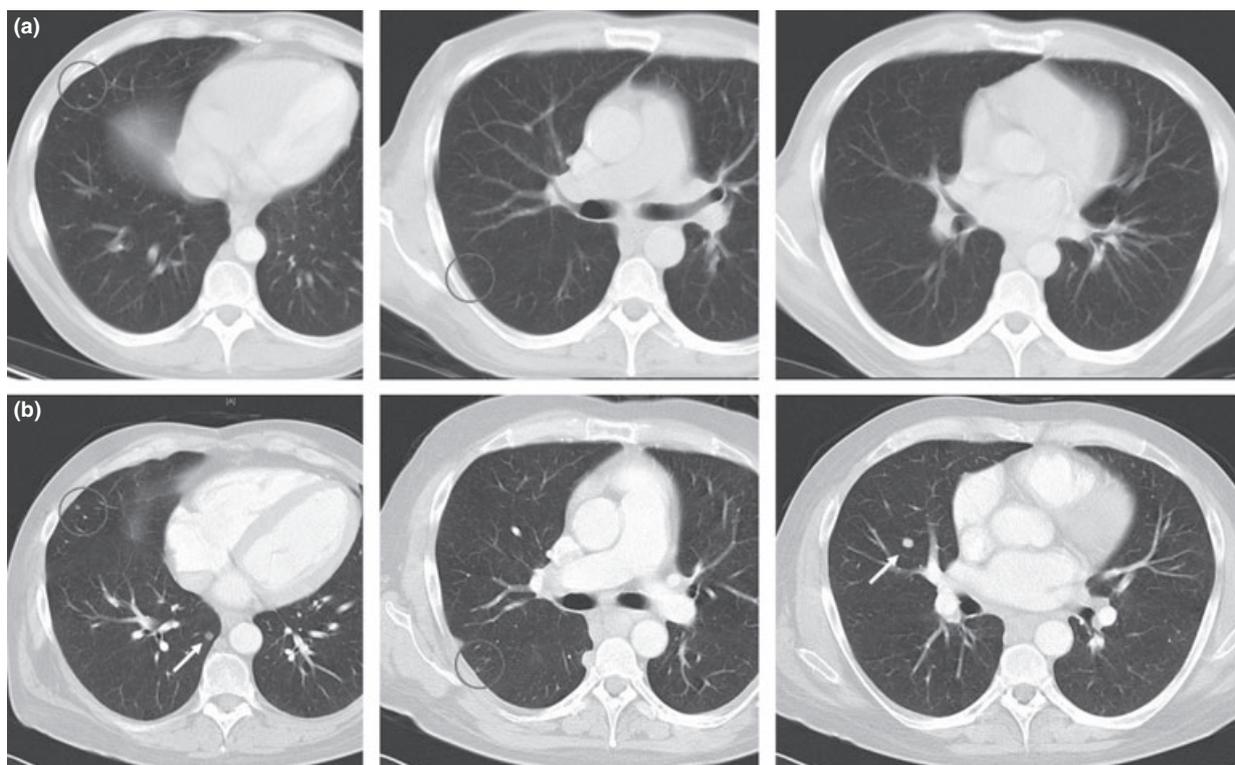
Patient no. 7 showed three small pulmonary nodules with different patterns on contrast-enhanced CT (a–lung window, high resolution kernel, 5-mm slice thickness). One lesion with calcification in right lower lobe, one lesion with ‘nonsolid’ density in the right upper lobe and one opaque lesion with 3-mm diameter in the left lower lobe. The control 10 months after LT (b–lung window, high resolution kernel, 5-mm slice thickness) showed multiple new intrapulmonary metastases in both lungs with unchanged appearance of the both previously diagnosed lesions in the right lung. The very small lesion in the left lung showed massive enlargement and was diagnosed as metastasis.
